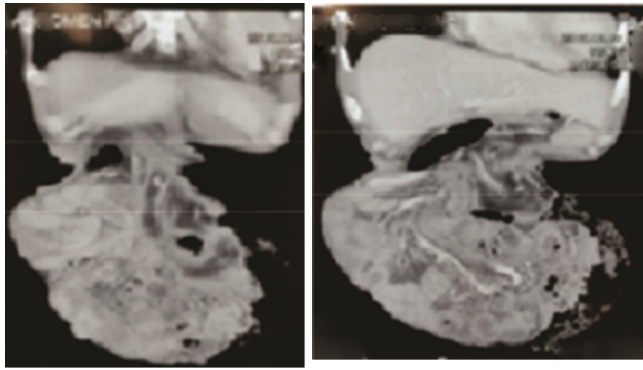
Fig-I A CT scan showing the herniation of the gut.
